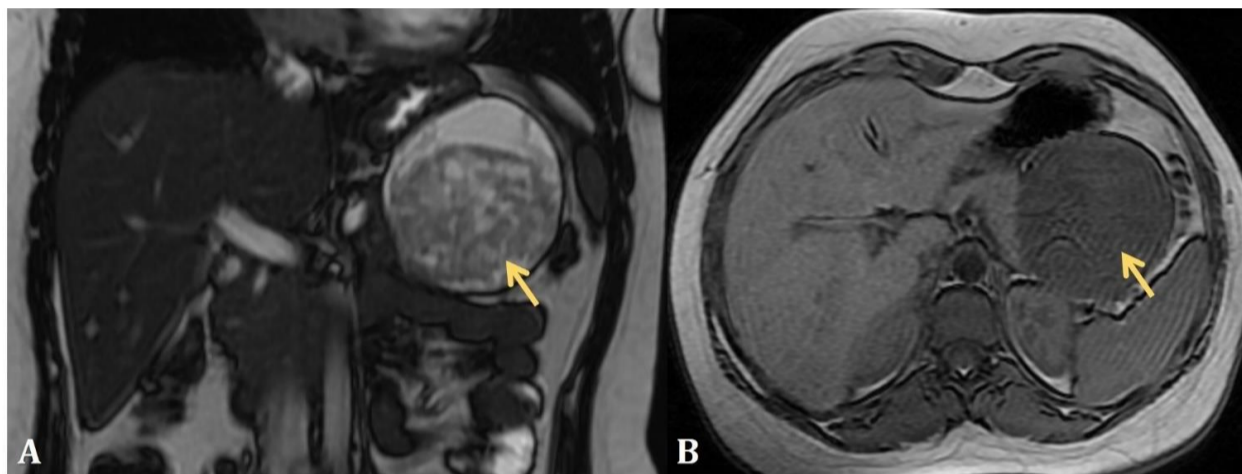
Coronal T2-W (A) and axial T1-W (B) abdominal MRI images showing a well- defined lesion of the pancreatic tail (yellow arrow), with a central cystic and peripheral solidportion, surrounded by a hypointense rim.
